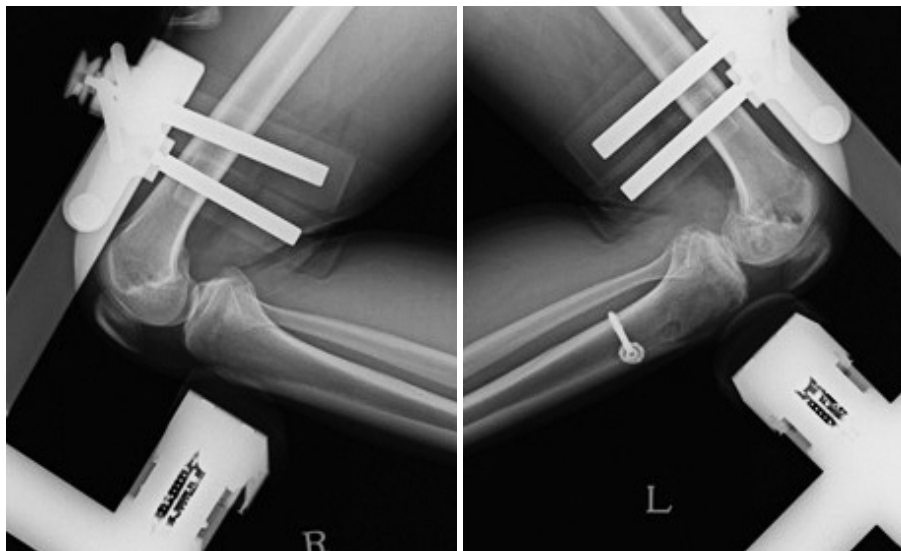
Postoperative posterior Telos stress radiographs. Posterior Telos stress radiography showing side-to-side differences in posterior instability at the sixth postoperative month in the same patient shown in Fig 1.
